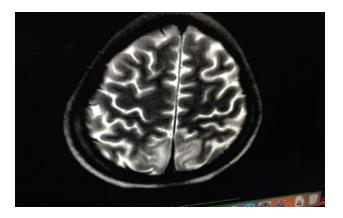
Biateral hypo intense signal in occipitial region on T1 weighted MRI.
